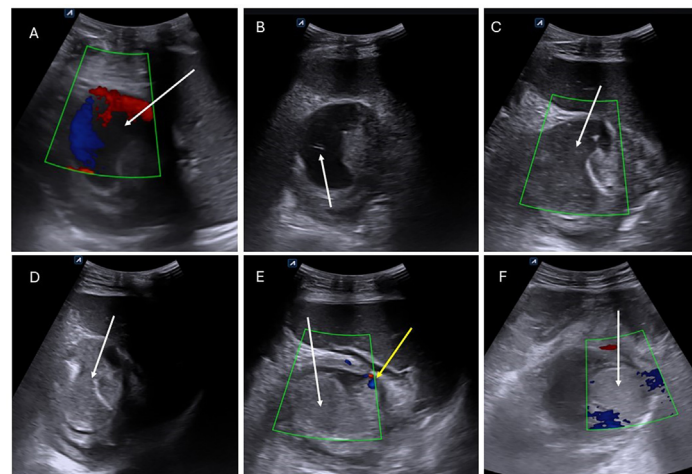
Case 1. Ultrasound guided percutaneous direct embolization of the pseudoaneurysm using the SAMEER technique. (A) Duplex scan of the pseudoaneurysm shows “ying-yang” flow within the pseudoaneurysm (white arrow). (B) Percutaneous puncture of the pseudoaneurysm with 18 G needle (white arrow). (C) Injection of a mixture of gelatin-based hemostatic foam slurry with autologous blood clot renders the lumen of the pseudoaneurysm echogenic (white arrow). (D) After an interval of 20 minutes, complete stasis of blood noted in the lumen of the pseudoaneurysm, and the lumen shows progressive increase in the echogenicity (white arrow). (E) Duplex ultrasound after placement of nylon suture coils within the sac of the shows complete thrombosis of the sac (white arrow). Note that the blood flow in the main splenic artery is still patent (yellow arrow). (F) Follow-up ultrasound doppler scan of the pseudoaneurysm shows complete persistent stable occlusion of the pseudoaneurysm (white arrow).
